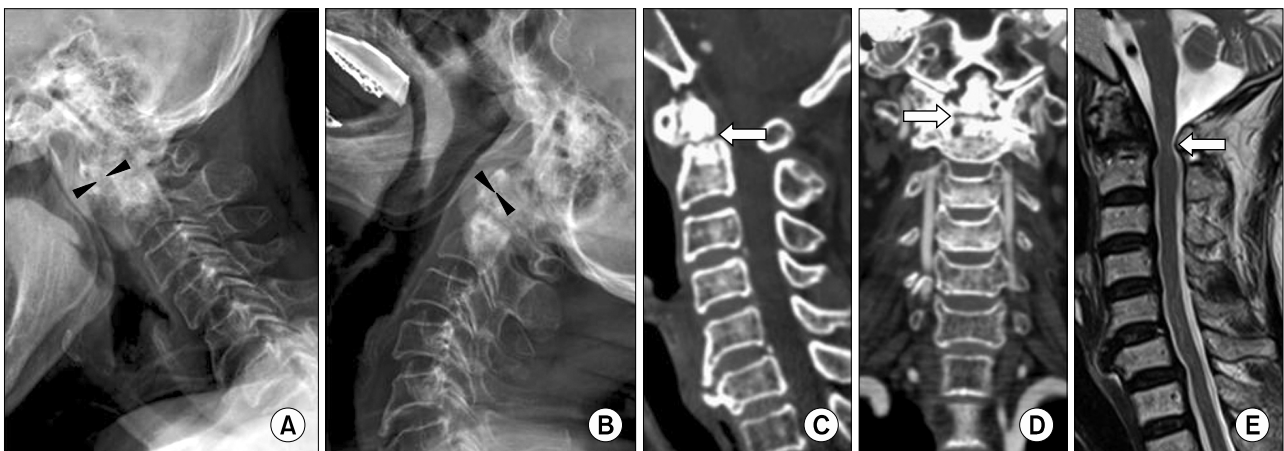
Lateral radiographs of the cervical spine in flexion (A) and extension (B). In flexion, the distance between the posterior aspect of the anterior ring of atlas and the anterior surface of the odontoid process (arrowheads) was 6 mm and showed atlantoaxial subluxation. Computed tomography scanning revealed a fracture of the odontoid process (C and D; white arrows). T2 weighted sagittal magnetic resonance imaging revealed C2 level spinal cord compression (E; white arrow).
